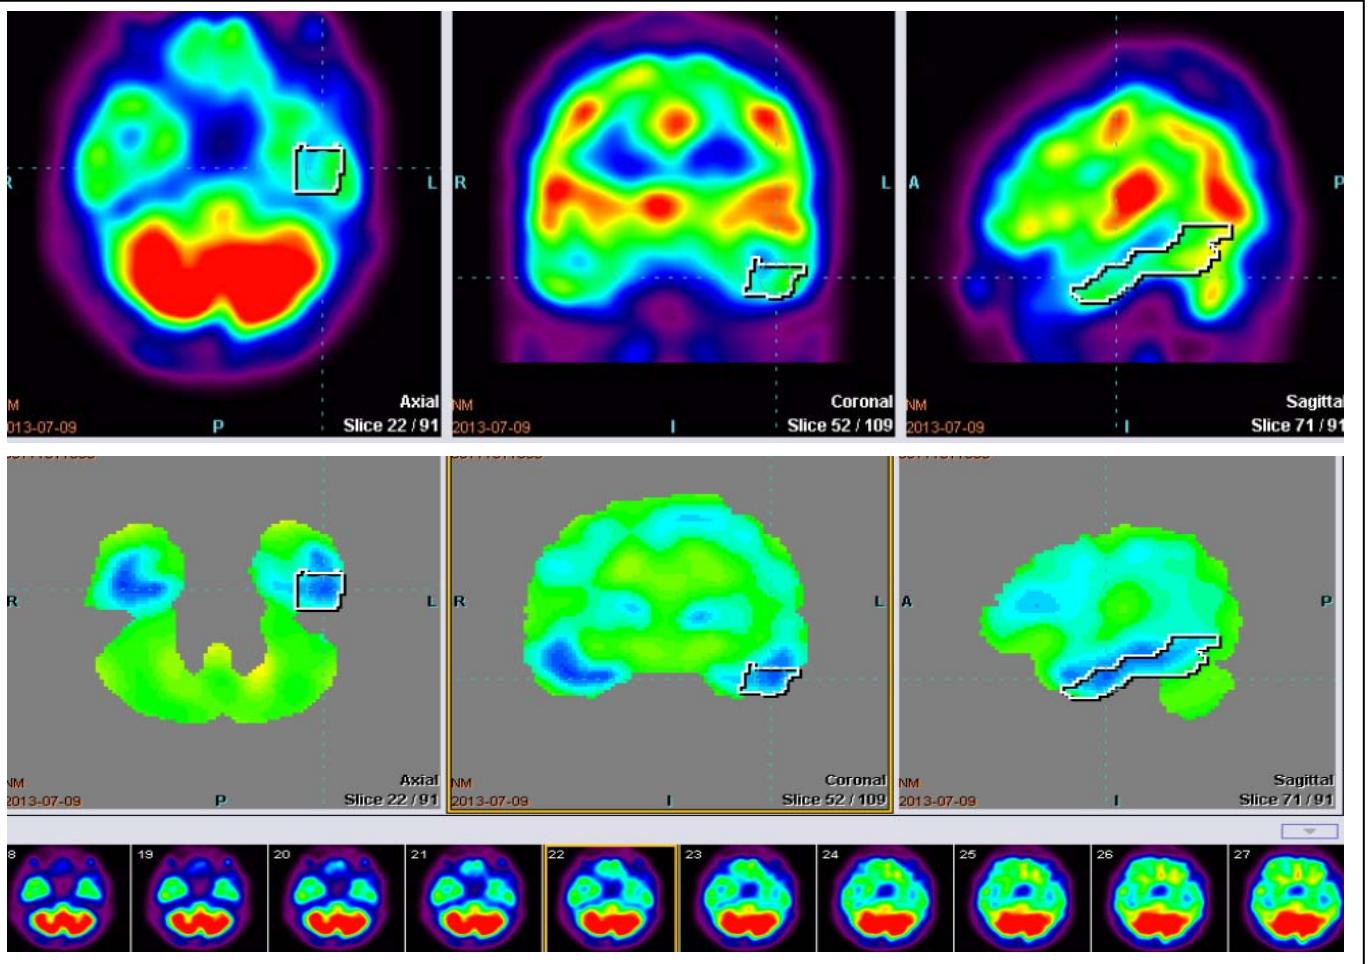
Example SPECT imaging data for inferior temporal gyrus (ROI marked in slice views). Two upper rows present different color maps for uptake values of the tracker. And bottom row present axial slices of uptake values.
